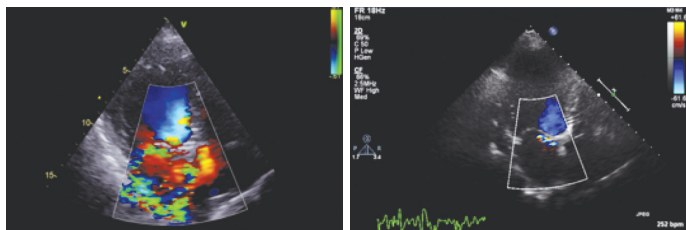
Comparison of pre- and post-procedural echocardiography.
